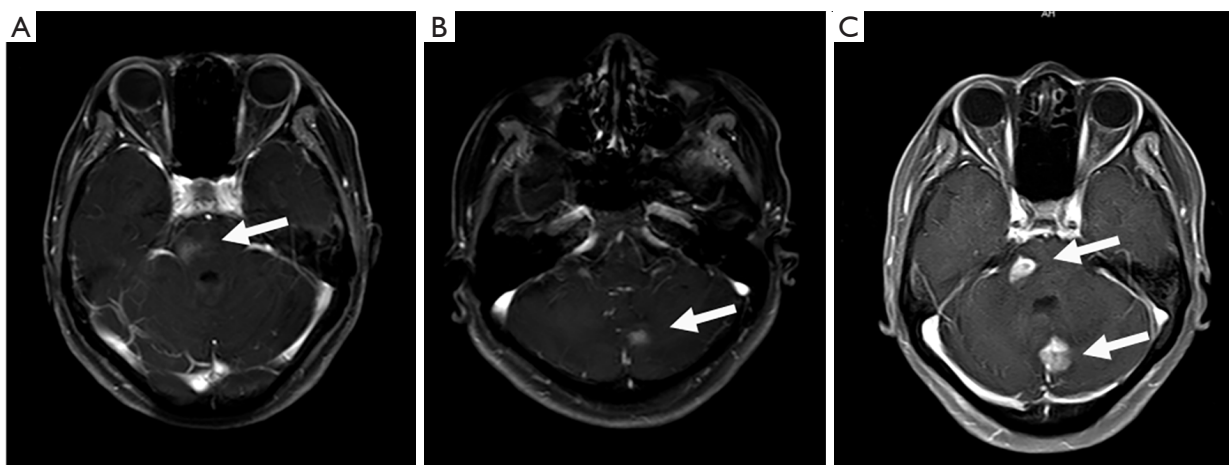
The brain MRI of the patient during the course of disease. (A) Brain metastasis in left cerebellar hemisphere after lung cancer surgery. (B) The left cerebellar hemisphere metastasis was significantly reduced after 1 month of gefitinib treatment. (C) New lesion appeared in the right parietal lobe after 40 months of gefitinib treatment. The arrows indicate the location of BMs. MRI, magnetic resonance imaging; BMs, brain metastases.
